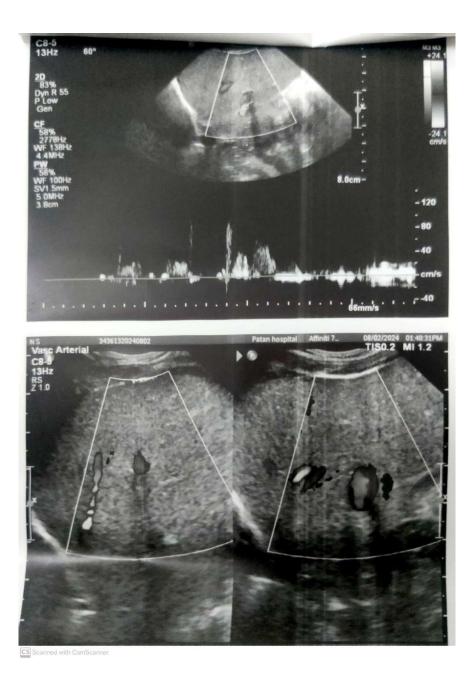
Ultrasound showing no evidence of thrombosis after 4 weeks of anticoagulant therapy.
